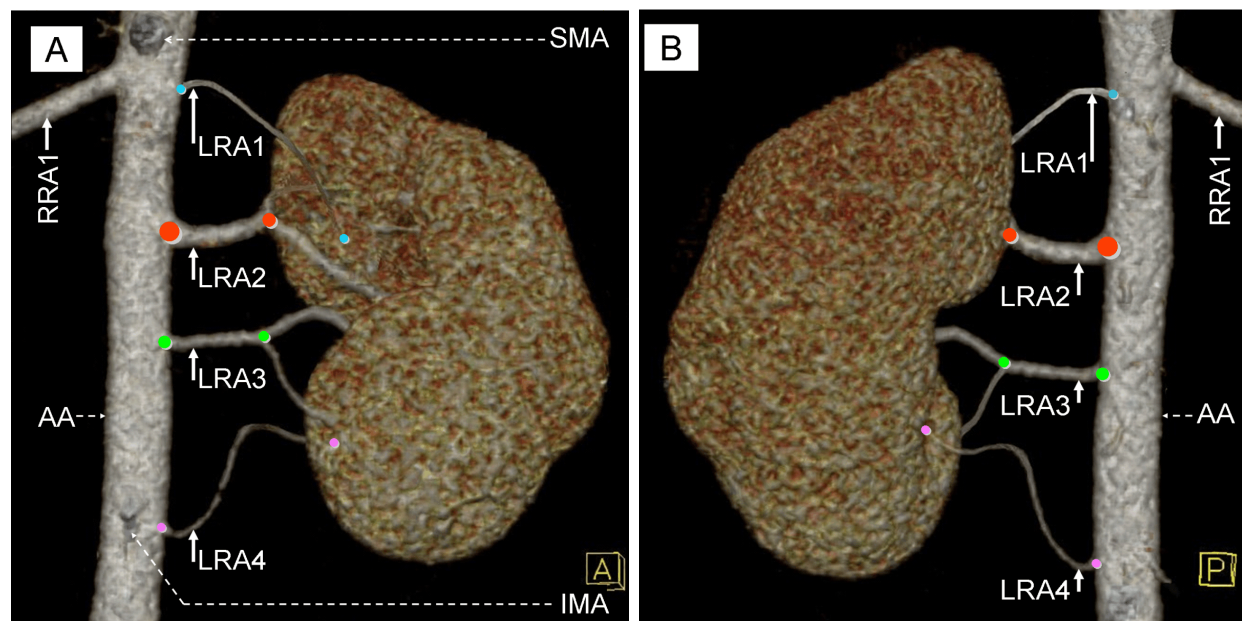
MDCT angiography of the left kidney. VRT images of the abdominal part of aorta shows the presence of four left RAs: (A) Anterior 3D VRT image shows the origin and the points of renal penetration of the left RAs, after subtraction of the skeletal structures; (B) Posterior 3D VRT image after subtraction of the skeletal structures. MDCT: Multidetector computed tomography; VRT: Volume rendering technique; RAs: Renal arteries; 3D: Three-dimensional; AA: Abdominal part of aorta; SMA: Superior mesenteric artery; IMA: Inferior mesenteric artery; RRA1: First right renal artery (right main renal artery); LRA1: First left renal artery (polar superior renal artery – AdRA); LRA2: Second left renal artery (left main renal artery); LRA3: Third left renal artery (middle-inferior renal artery – AdRA); LRA4: Fourth left renal artery (polar inferior renal artery – AdRA); AdRA: Additional renal artery. With colored dots: Points of left RAs origin at aortic level; Points of left RAs penetration (or bifurcation).
